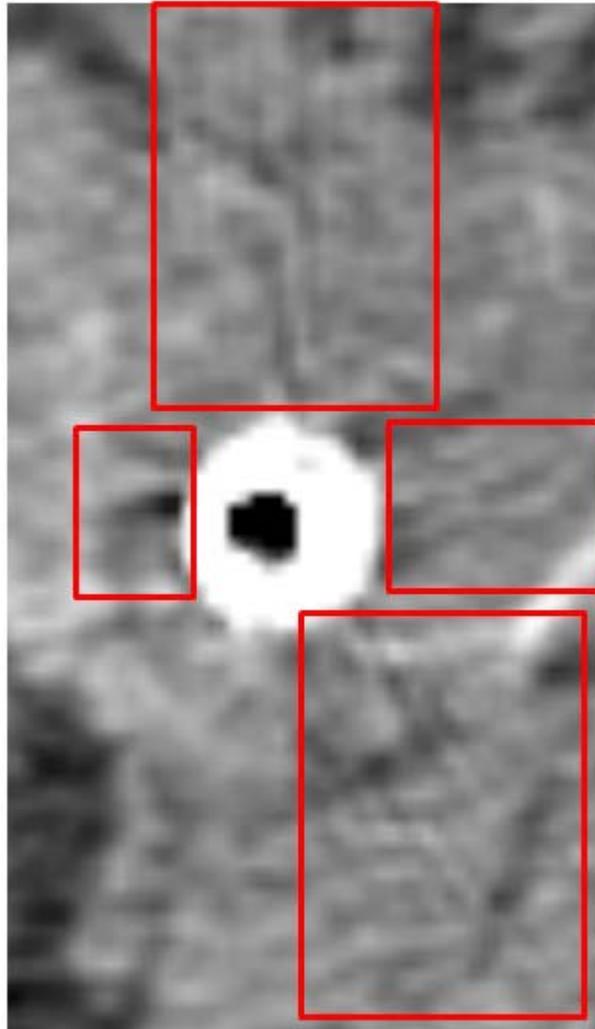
Contrast CT scans showing each identified directional component of the beam-hardening artifacts caused by biliary stents. The components are identified in red boxes indicating the crop extents.
